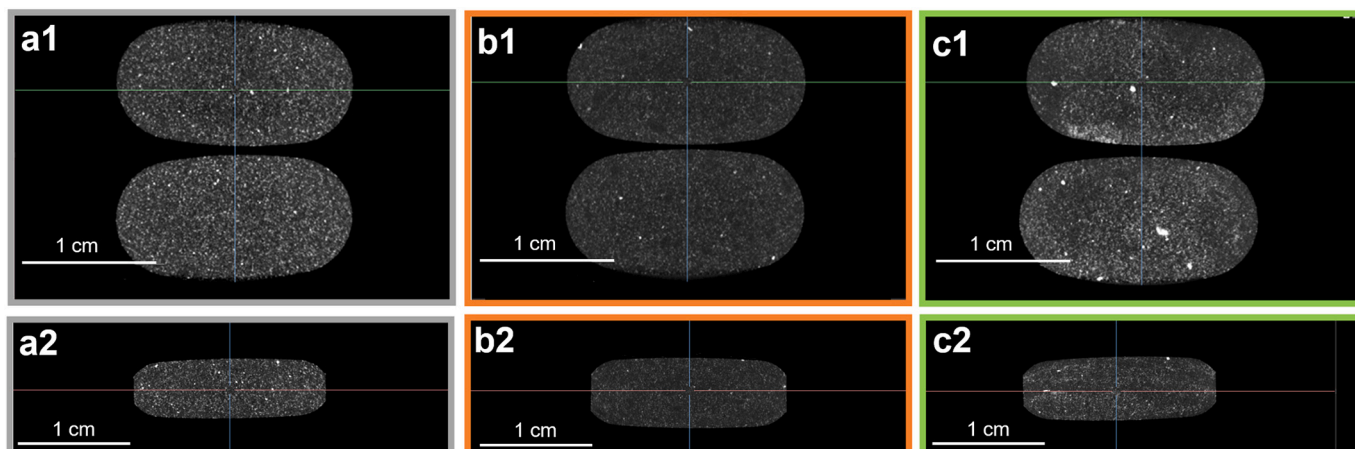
X-ray μ CT images ((1) radial; (2) axial cross section) of TB tablets: (a) HME; (b) SD; (c) VDD.
